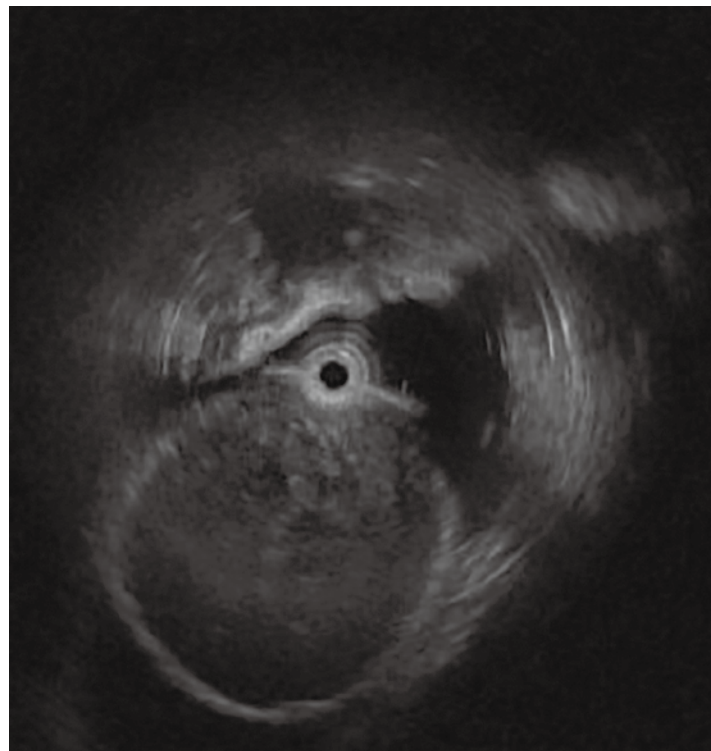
Endoscopic ultrasonography
